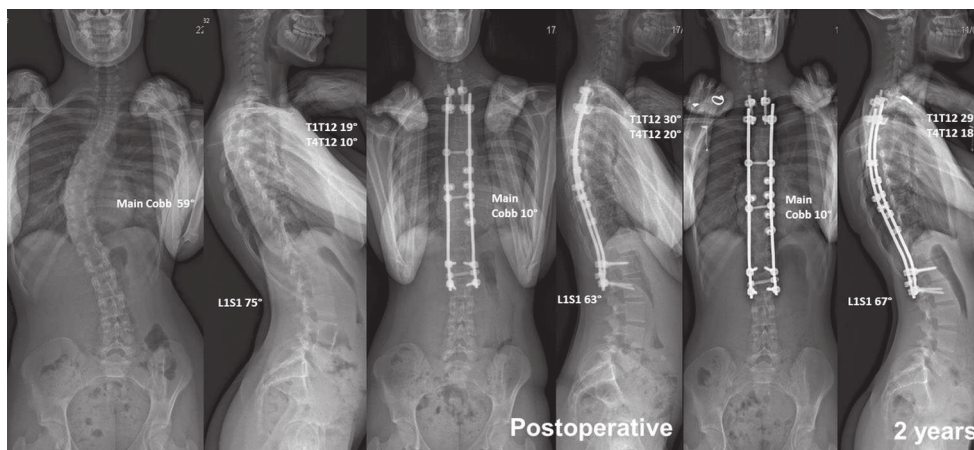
Preoperative, postoperative and latest anteroposterior and lateral radiographs of a Lenke 1 AIS patient, showing a 4° spontaneous increase in T4T12 kyphosis during follow-up
